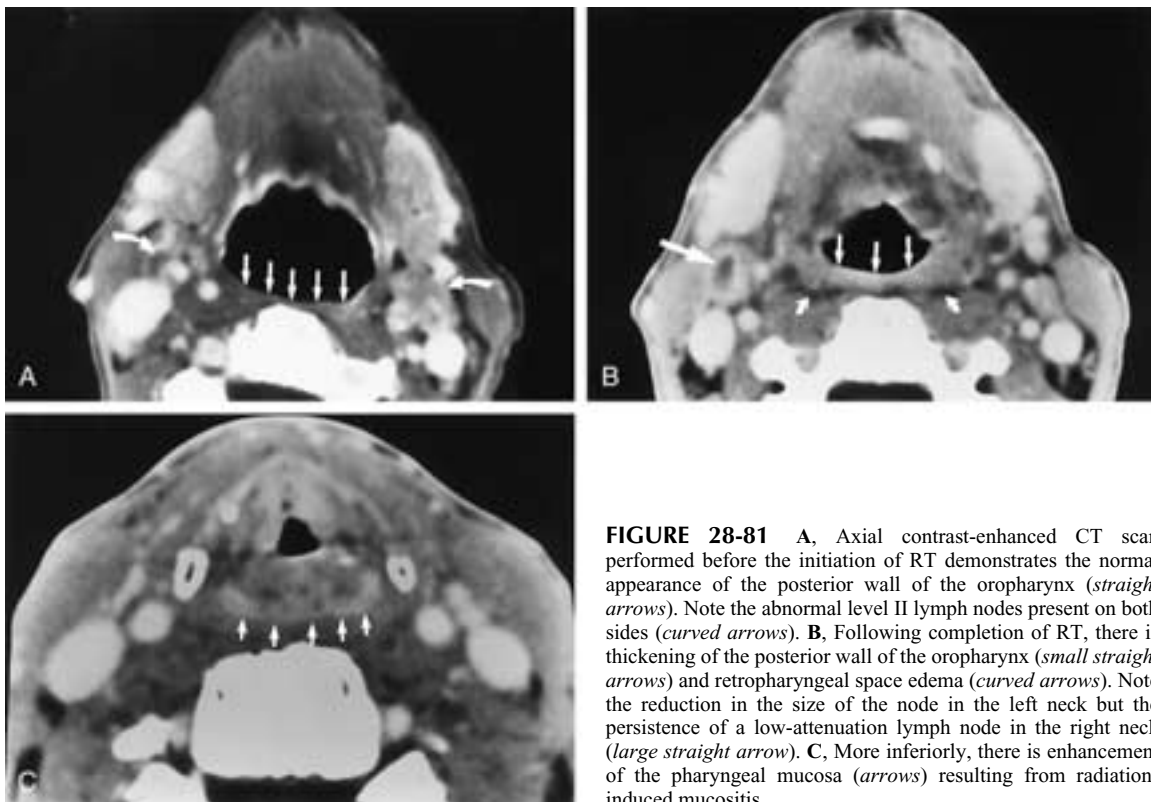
A, Axial contrast-enhanced CT scan performed before the initiation of RT demonstrates the normal appearance of the posterior wall of the oropharynx (*straight arrows*). Note the abnormal level II lymph nodes present on both sides (*curved arrows*). B, Following completion of RT, there is thickening of the posterior wall of the oropharynx (*small straight arrows*) and retropharyngeal space edema (*curved arrows*). Note the reduction in the size of the node in the left neck but the persistence of a low-attenuation lymph node in the right neck (*large straight arrow*). C, More inferiorly, there is enhancement of the pharyngeal mucosa (*arrows*) resulting from radiation-induced mucositis.
